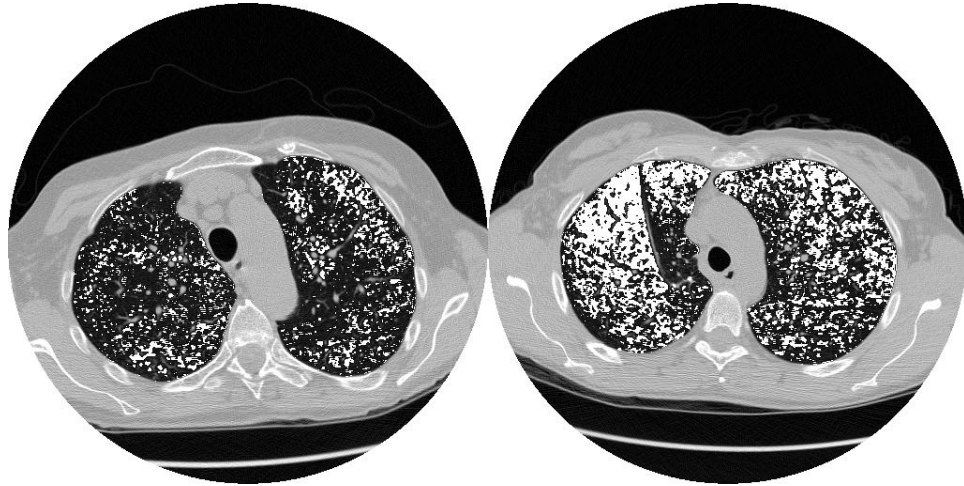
Calculation of Emphysema Index (EI) from CT Through Density Masking. Left) Axial slice depicting relatively mild emphysema (EI \sim 17%). Right) Axial CT slice depicting relatively severe emphysema (EI \sim 39%). Emphysematous regions in the lung field are shown in white.
